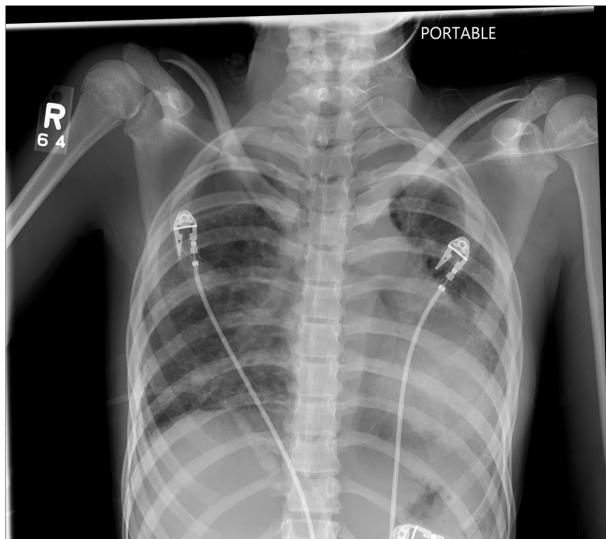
Admission Chest x-ray showing a large Right side Pneumothorax, Left pleural effusion at the lung apex and mild bilateral interstitial edema.
